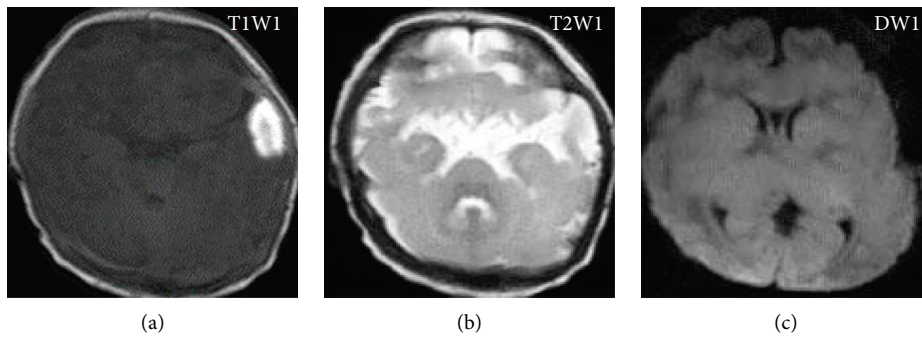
MRI imaging of premature infants with brain injury: (a) T1-weighted image; (b) T2-weighted image; (c) diffusion-weighted imaging.
